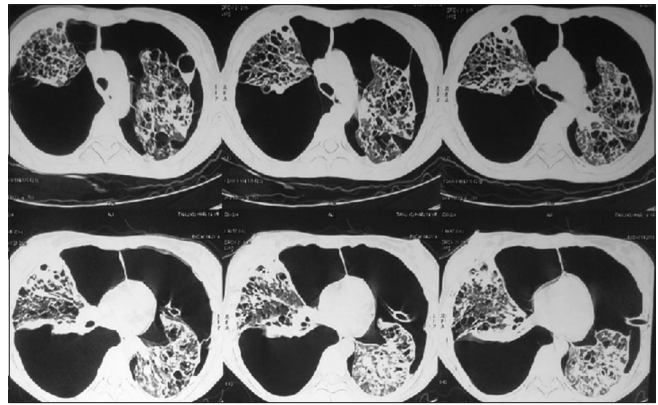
Computed tomography chest showing extensive bilateral pneumothoraces with multiple parenchymal lung cysts
